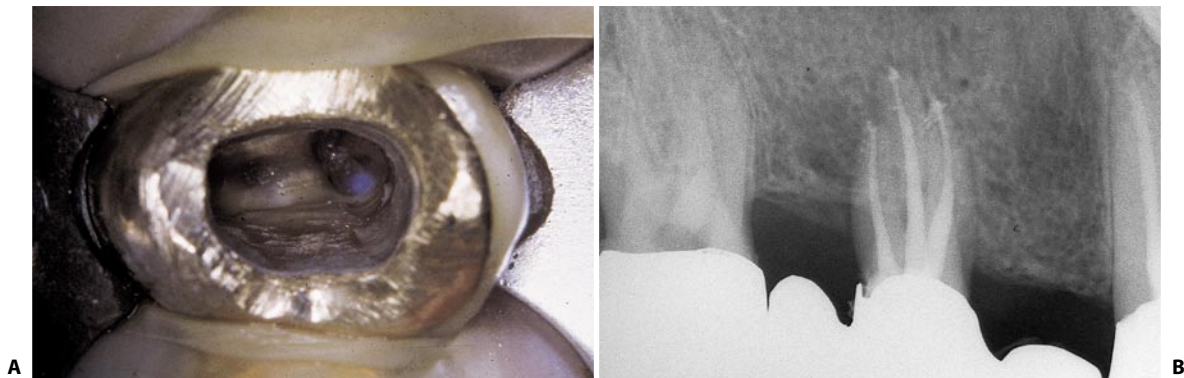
A. Careful examination of the pulp chamber floor of this upper right second premolar reveals the presence of one palatal and two buccal orifices. B. This postoperative radiograph confirms the presence of three canals in three independent roots.
